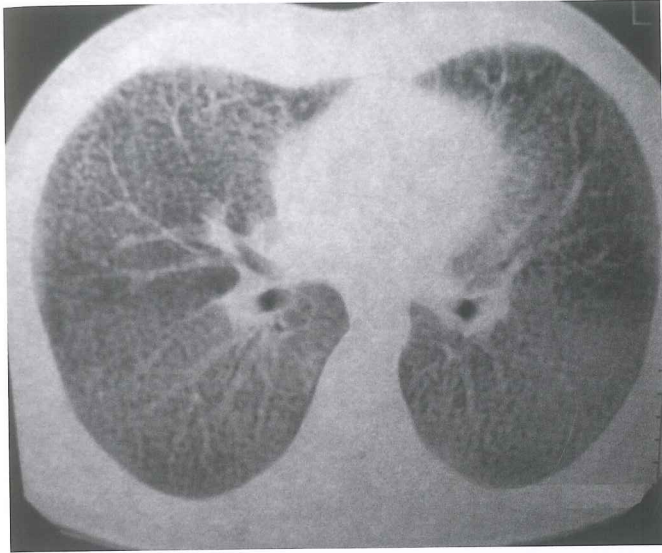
CT scan showing ground glass appearance mainly in lower lobes.
